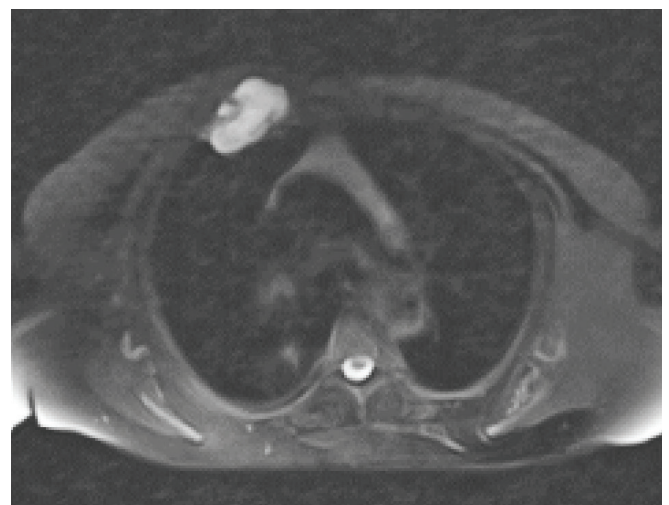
Magnetic resonance imaging showing the localization of the hamartoma.
